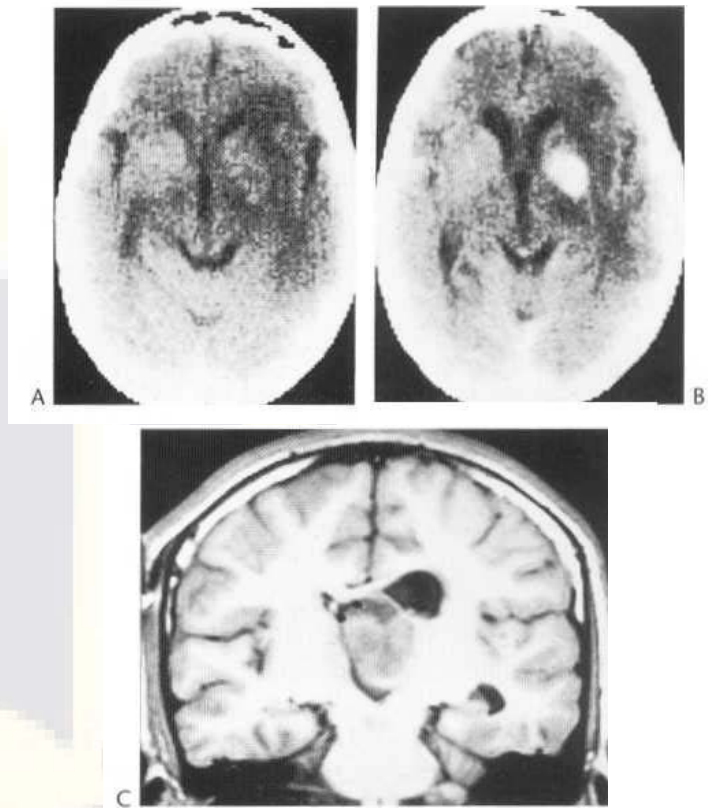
Lymphoma of brain. (A) CT before contrast. (B) After contrast. Isodense tumour with little mass effect enhances strongly with contrast. (C) MRI, T₁-weighted, in another patient. Low-density paraventricular mass involves thalamus and extends into third and left lateral ventricles.
